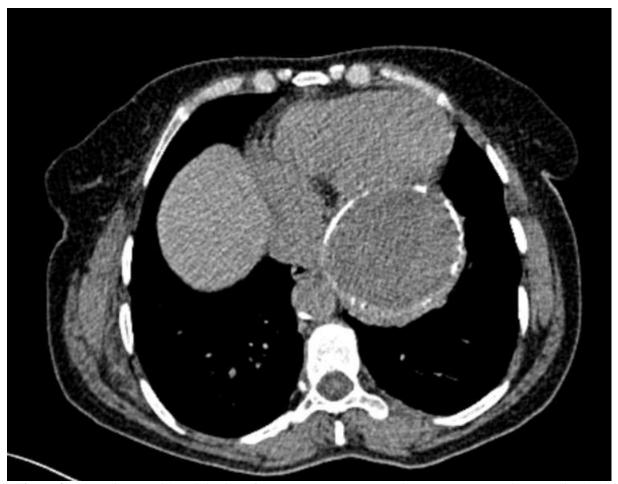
Thoracic CT (without injection of the contrast product) showing the mass suspecting a cardiac hydatid cyst, stuck to the left cardiac chambers.
